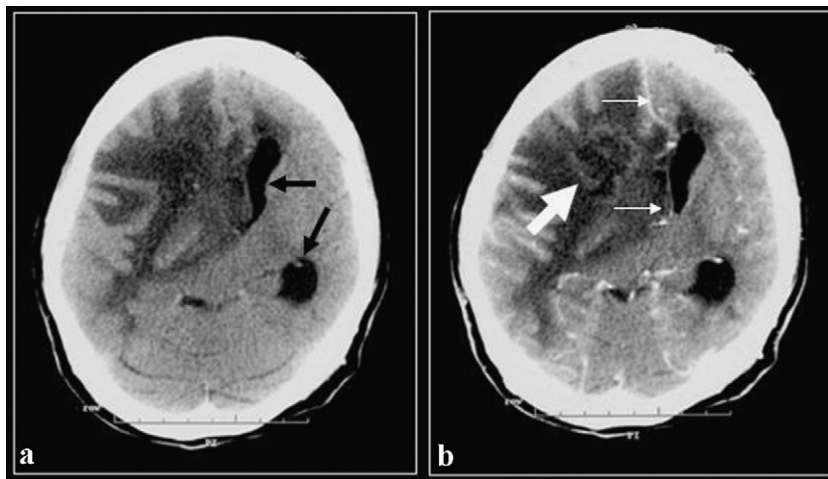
(a) Plain and (b) contrasted CT of the brain (WW=80, WC=40) show a ring enhancing lesion (thick white arrow) in the right frontal lobe with associated marked perilesional oedema, mass effect and midline shift of 1.5 cm to the opposite side (thin white arrows). There is also contralateral hydrocephalus (black arrows).
